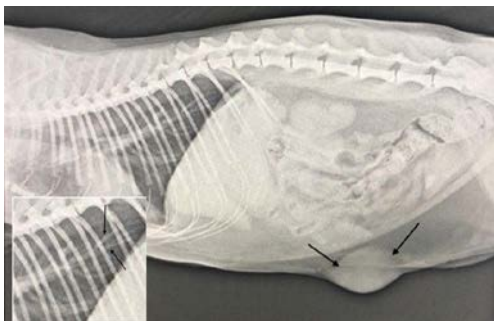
Radiographic view of the mass in the caudal abdomen and metastatic masses in the left caudal lobe of the lung (metastatic masses are seen in the inset)
